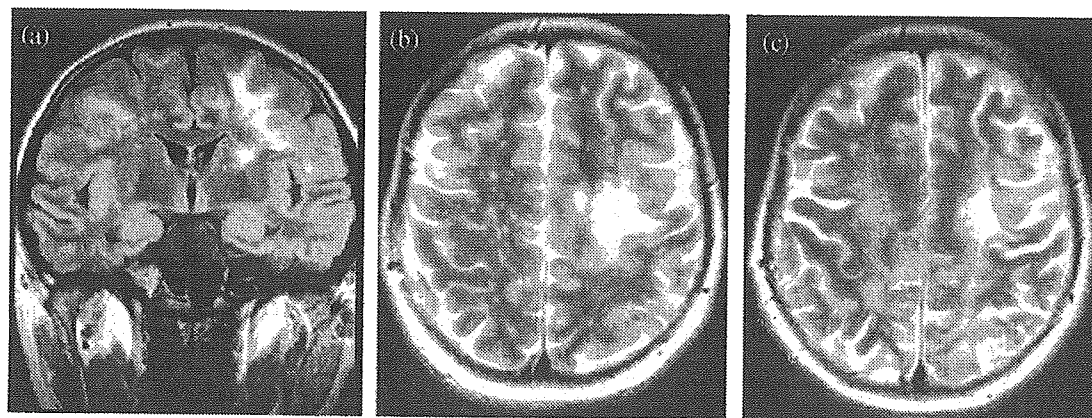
Cranial MRI (a and b, on November 2001; c, on April 2003). (a) Coronal FLAIR image, showing large high-intensity lesion in the subcortical white matter of the left frontal lobe. (b) Axial T2 weighted image, showing multifocal high-intensity lesions in the bilateral frontal lobes. (c) Following α -interferon therapy, axial T2 weighted image demonstrating no new lesions that might indicate recurrence of PML.
